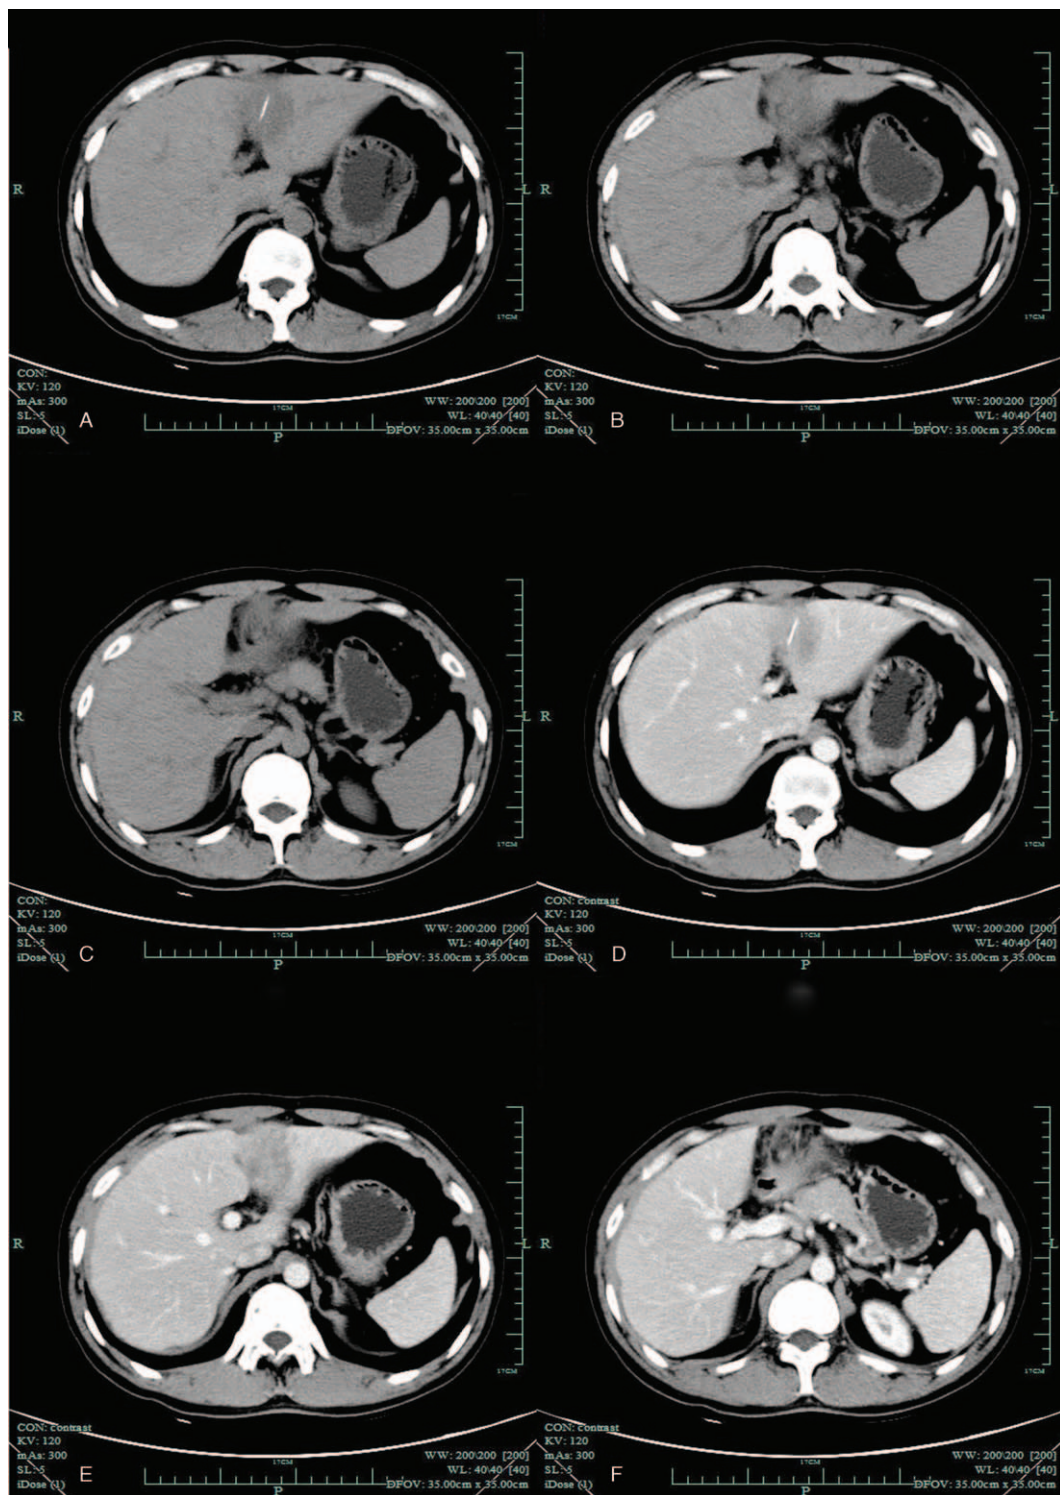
Plain and contrast-enhanced CT scan: a hyperdense linear foreign body embedded in a hypodense mass within segment 3 of the liver. The surrounding lesser omentum between the mass and gastric antrum become edematous and thickened. (A, B, and C: plain scan; D, E, and F: contrast-enhanced scan). CT = computed tomographic.
